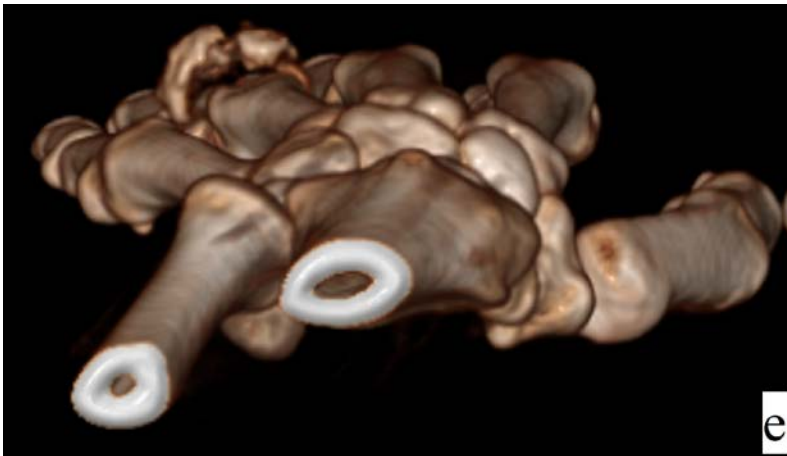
3D CT scan, an axial projection*
